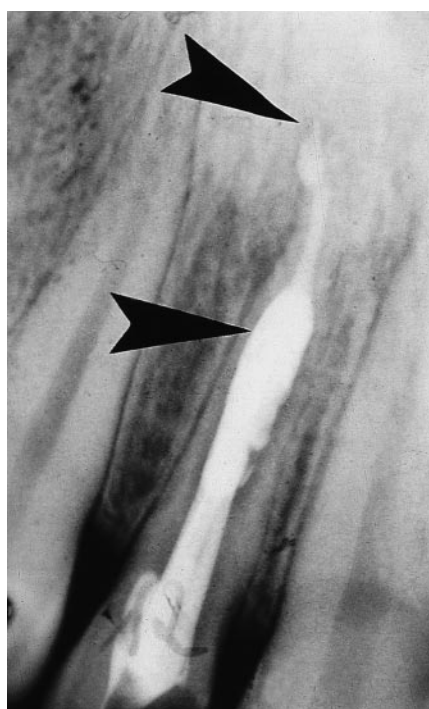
Ante-mortem x-ray of the root filling of tooth 12 obtained from the dentist of the suspected victim (case report)
